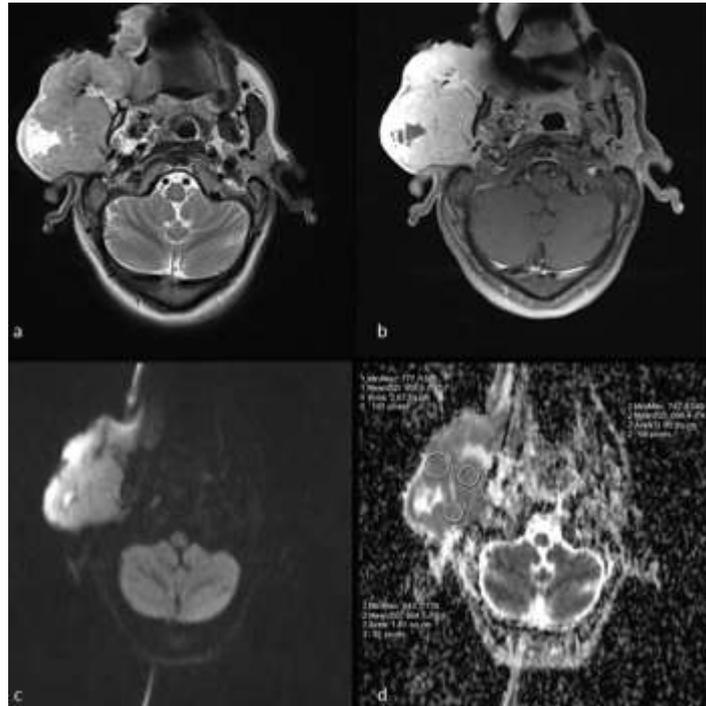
Excluding the cystic/necrotic portions from ROI in a case of epidermoid carcinoma. a. Axial T2-weighted image b. Axial contrast fat suppressed T1-weighted image c. DWI d. ADC map (0.95×10^{-3} mm²/s, 0.89×10^{-3} mm²/s and 0.96×10^{-3} mm²/s)
